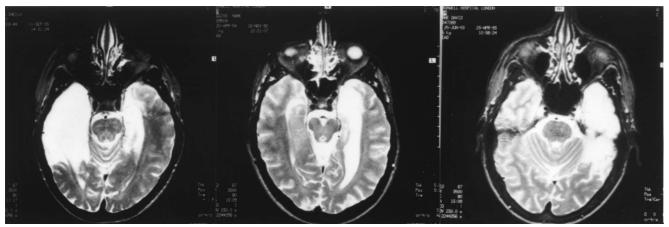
Axial MRI views of patients with (a) predominantly right-sided, (b) predominantly left-sided, (c) unilateral left-sided pathology (all herpes encephalitis).
